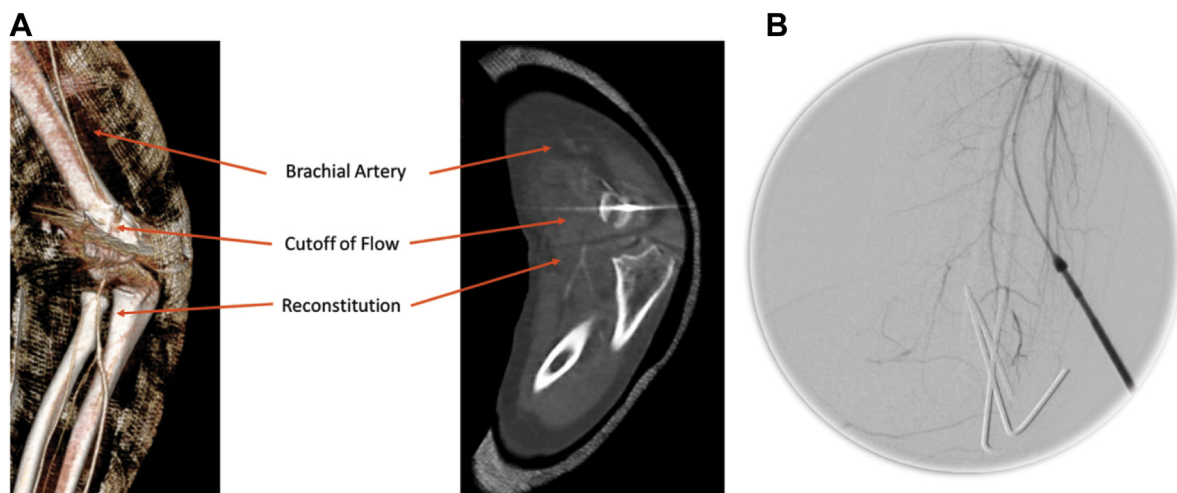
A, Computed tomography angiogram showing cutoff of flow from the brachial artery at the elbow at the level of the fracture on both three-dimensional rendering and two-dimensional scans. B, Initial angiogram showing lack of flow distally in the brachial artery.
